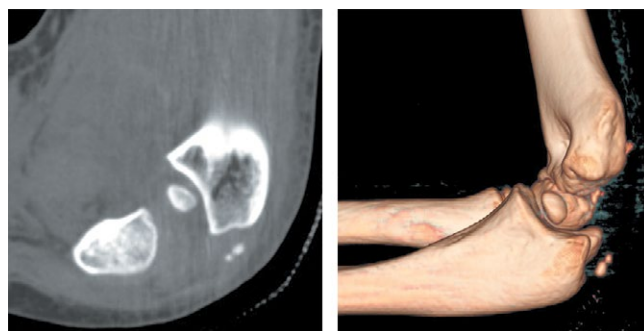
Patient S. Post reduction CT-scan with 3D reconstruction shows ME intraarticular entrapment
